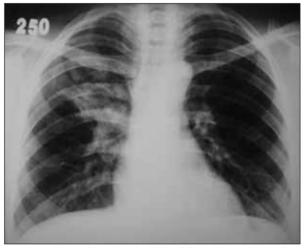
Chest radiography showed radiological regression in the third month of treatment
